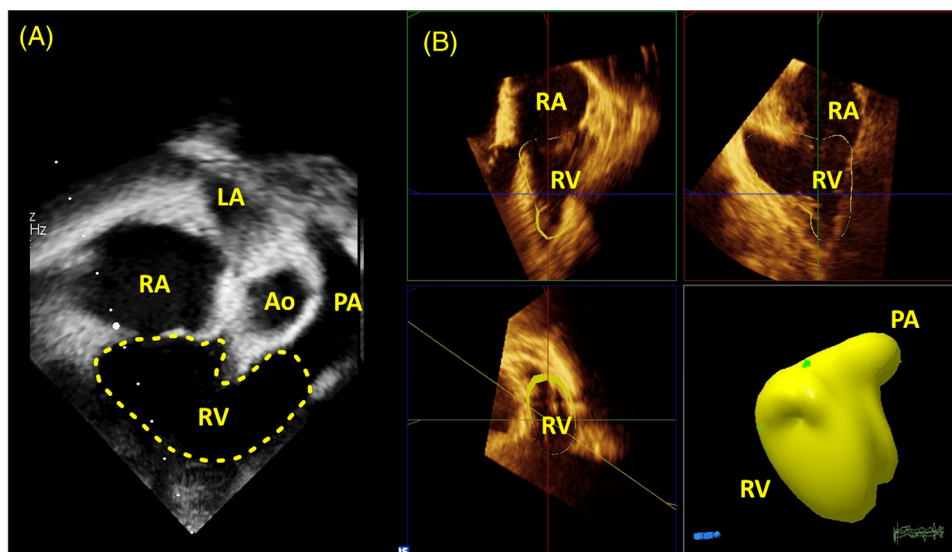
(A) Transthoracic echocardiography showing a non-atrialized part of the right ventricle (dash line). (B) Three-dimensional echocardiographic reconstruction of the right ventricle. Ao, aorta; LA, left atrium; PA, pulmonary artery; RA, right atrium; RV, right ventricle.
